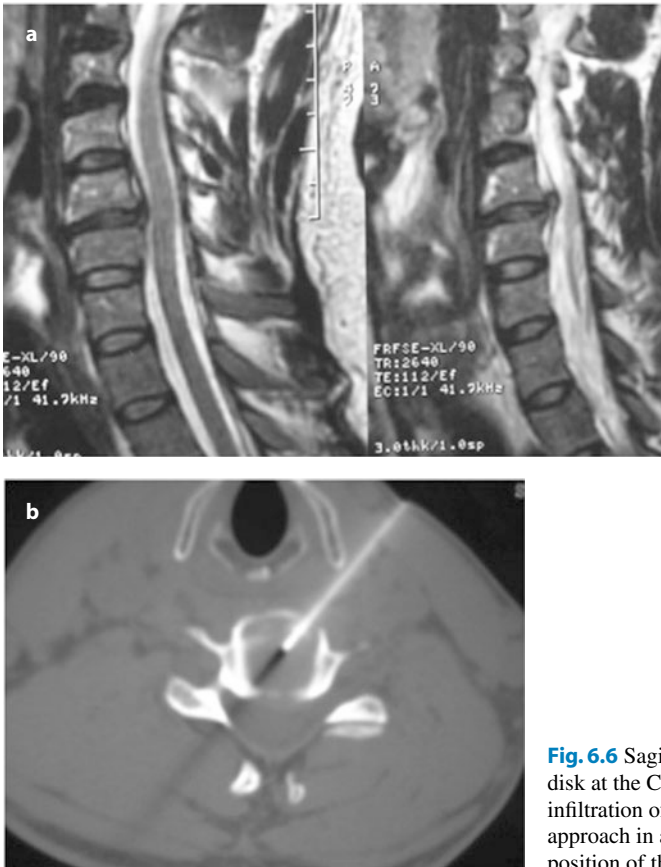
Sagittal T2-weighted MRI shows a herniated disk at the C5–C6 level (a). Axial CT during intradiscal infiltration of an O₂–O₃ mixture using a right anterolateral approach in a patient in the supine position shows the position of the needle in the disk (b)
